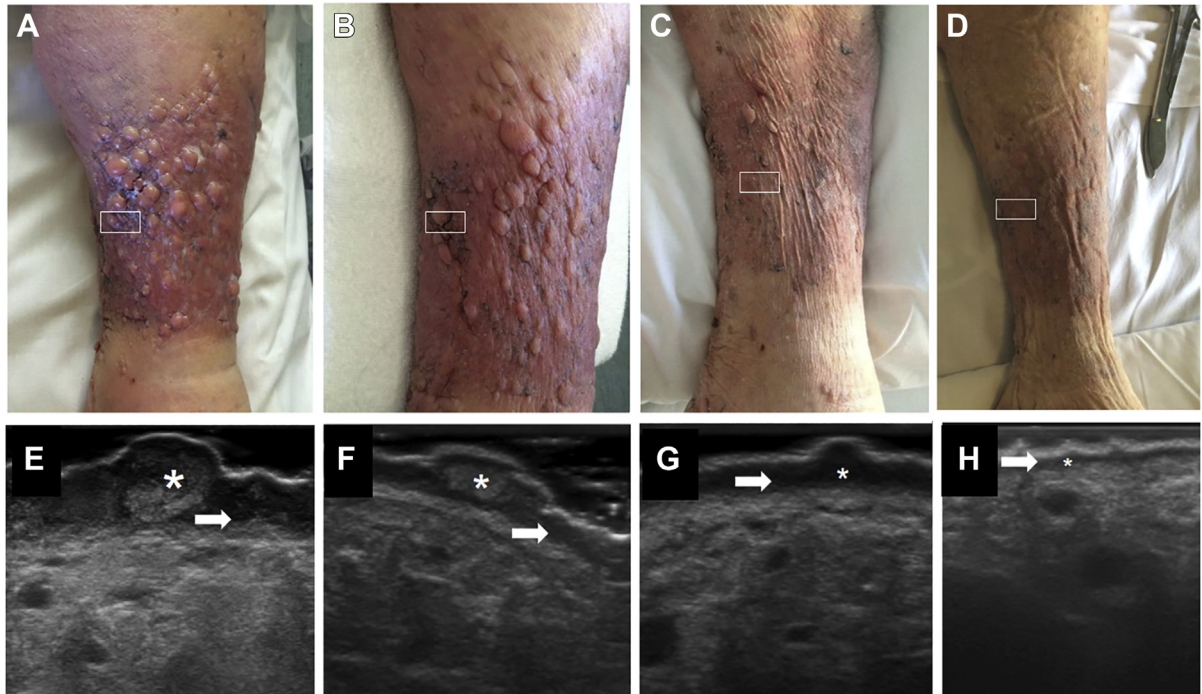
Patient G.L., 84 years old. Verrucous hyperplasia of the skin (VHS) clinical (A-D) and ultrasound (E-H) changes related to compression. The areas displayed by ultrasound are marked. Before treatment (A and E) and after 2 weeks (B and F), 4 weeks (C and G), and 6 weeks (D and H) of compression treatment. Compression induces a progressive reduction of the papillary dermis edema (*arrows*) and of fibrous proliferation of the reticular layer (*).
